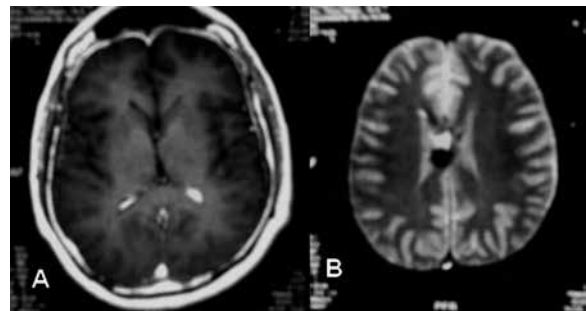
Head MRI on postoperative, T1 with contrast (A) and T2 (B), showing no evidence of macroscopic intraventricular lesion.
